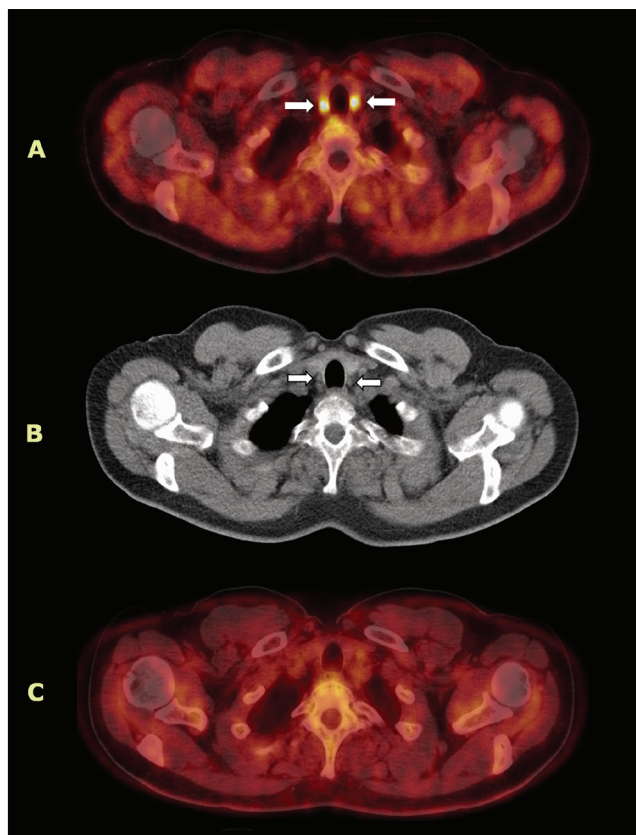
A. Axial scan of F-18-Choline PET/CT demonstrated two foci (arrows) of markedly increased uptake localized posteriorly to both inferior parts of the thyroid lobes; B. Hyperfunctioning parathyroid glands on CT axial scan (arrows), the diameters of the glands were: 4x4mm on the right side and 8 × 5mm on the left; C. F-18-Deoxyglucose PET/CT scan was negative for abnormal uptake in this region
